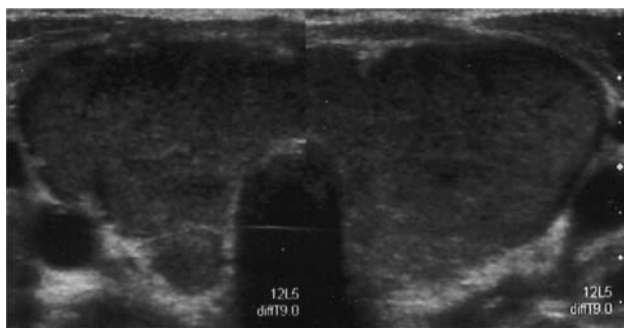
Ultrasonogram of the thyroid gland showing a finely and diffusely nonhomogenous structure
